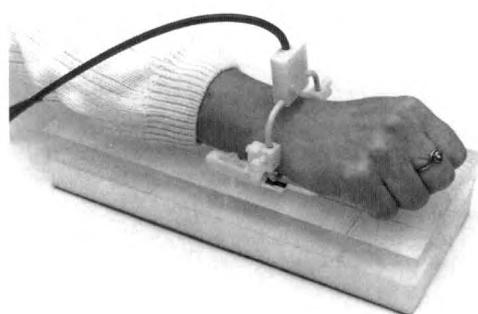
Two-piece receiver coil used for MR imaging of ligaments of wrist.
